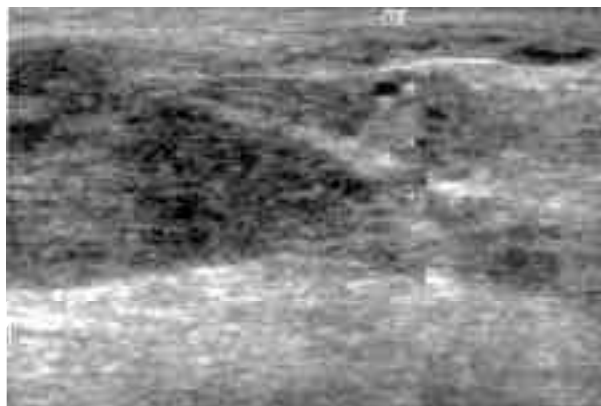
Ultrasound evaluation of the cord showing the upper pole of the testis and hypoechoic mass in the cord
